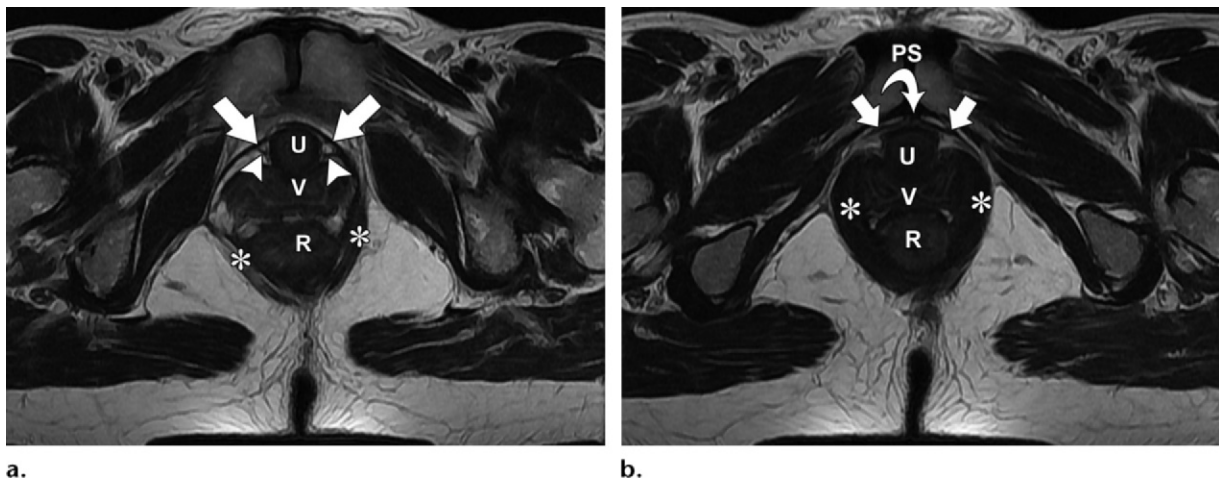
Normal female pelvic floor anatomy. Axial T2-weighted MR images show the ligaments that support the female urethra at superior (a) and inferior (b) levels: the periurethral ligaments (arrows), which arise from the puborectalis muscle (*); paraurethral ligaments (arrowheads in a), which arise from the lateral wall of the urethra (U); and periurethral and pubourethral ligaments (curved arrow in b), which arise from the pubic bone and extend to the ventral wall of the urethra. Note the typical H- or butterfly-like shape of the vagina (V) and the close apposition of the puborectalis muscle to the vaginal wall. *PS* = pubic symphysis, *R* = rectum.
